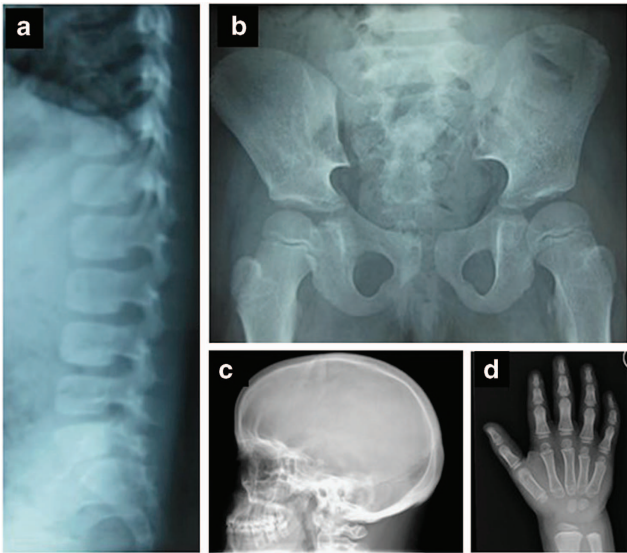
Radiological manifestations of Myhre syndrome. (a) AP view of the vertebrae (at 3 years of age), (b) pelvic and (c) skull X-ray (at 12 years of age) and (d) hand X-ray (at 2 years of age) of an MS patient. Note the thick pedicles of the vertebrae, short femoral neck, thick calvaria, delayed bone age and generalized brachydactyly.
